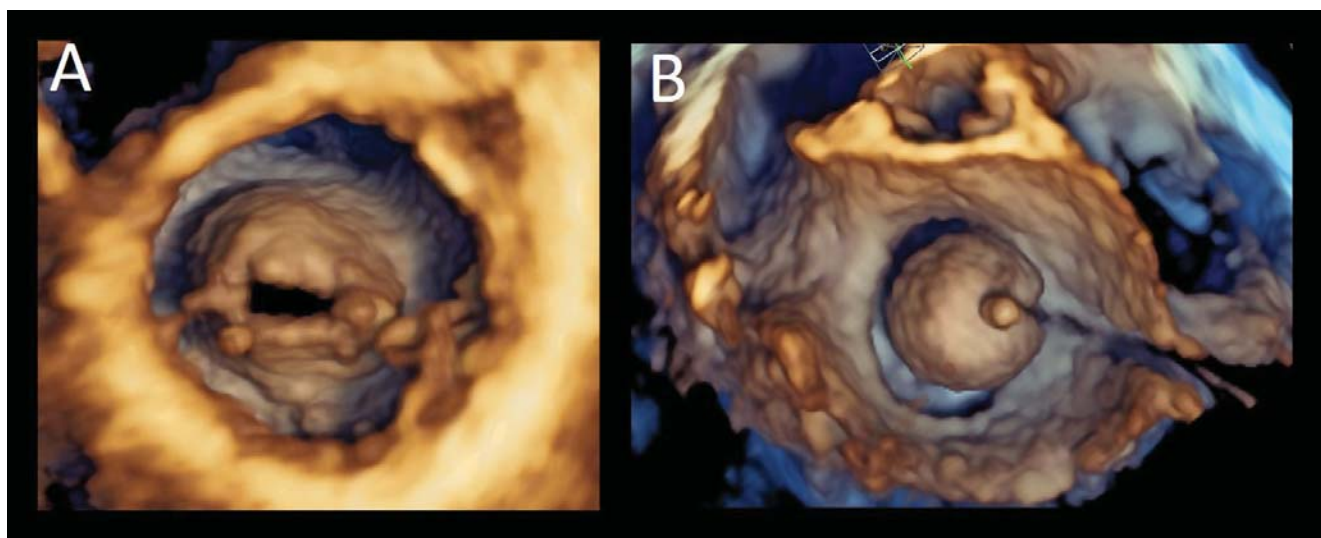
Mitral valve stenosis before and during balloon valvuloplasty. Transesophageal three-dimensional volume rendering visualization of the rheumatic mitral stenosis. The visualisation of the valve from the ventricular perspective (Panel A) allows to appreciate the leaflet morphology, the extent of fusion commissures and the area of the residual opening orifice. The same ventricular perspective can be used during the percutaneous mitral balloon valvuloplasty to monitor the procedure (Panel B).
